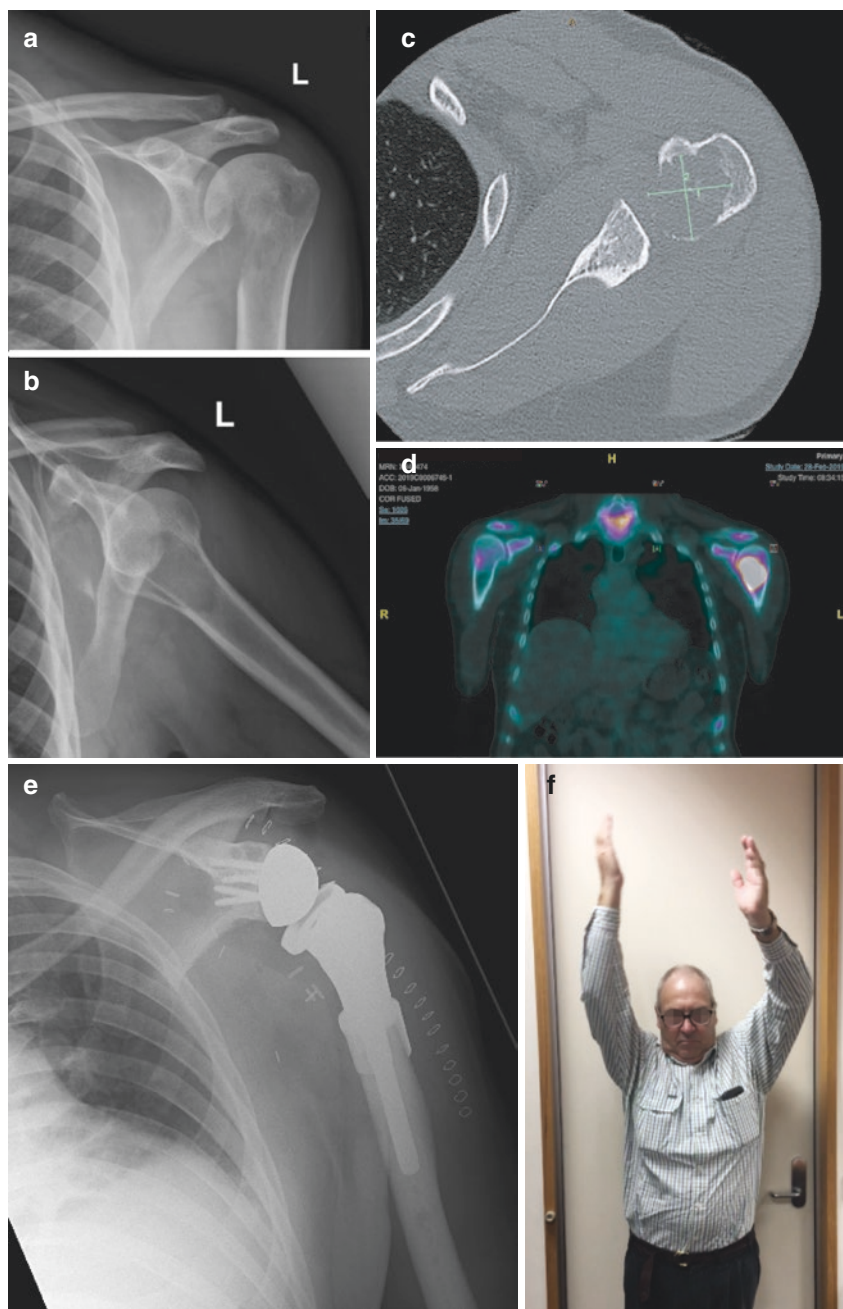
(a) Anteroposterior and (b) axillary lateral plain radiographs of the shoulder demonstrating a large lytic lesion of the proximal humerus. (c) CT scan of the shoulder demonstrating destructive changes extending into the humeral head. (d) Thallium scan demonstrating local hypermetabolic tumour. (e) Following resection, the proximal humerus was reconstructed with a reverse shoulder tumour endoprosthesis. (f) Despite the loss of the supraspinatus tendon, the reverse shoulder mechanism permits a reasonable level of post-operative arm abduction
